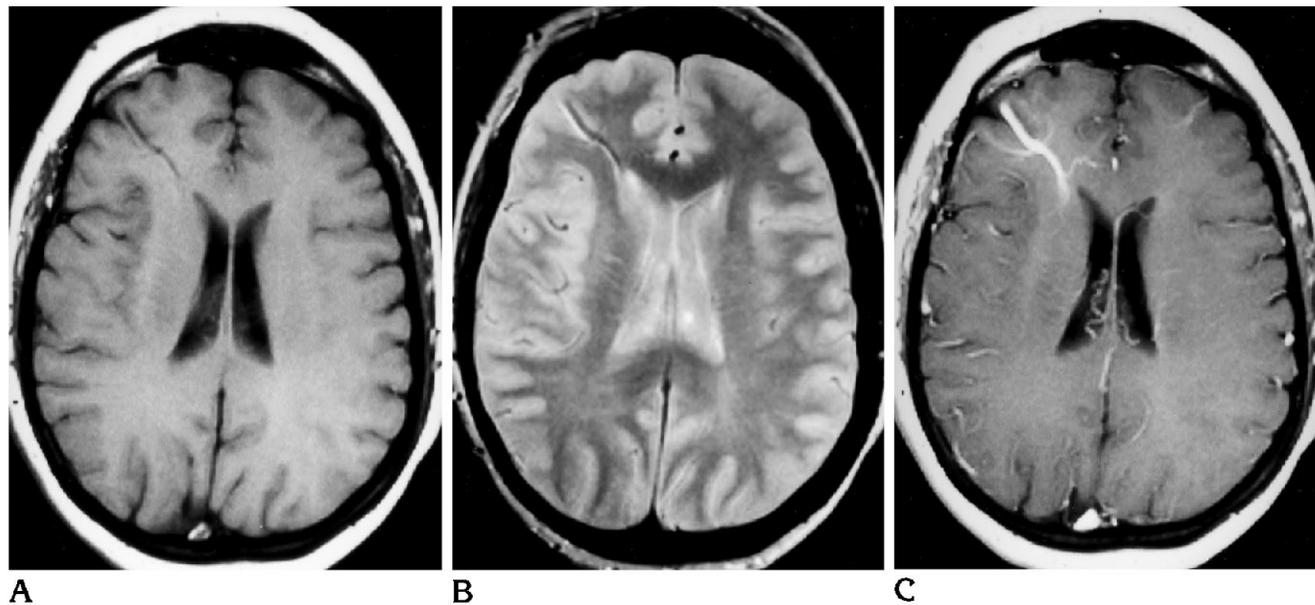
Deep DVA with superficial draining vein. Comparison of unenhanced T1-weighted (A) intermediate T2-weighted (B), and contrast-enhanced T1-weighted (C) MR images of a left frontal deep DVA. Portions of the caput are seen best on the contrast-enhanced T1-weighted image (typical caput is seen better on next higher image, not included). The collector vein is seen well in all images, probably because of its large size. Despite the caput's not being seen on unenhanced T1- and T2-weighted images, DVA is the most likely diagnosis because of the markedly enlarged medullary vein. However, differentiation from an AVM may be difficult without contrast imaging.
